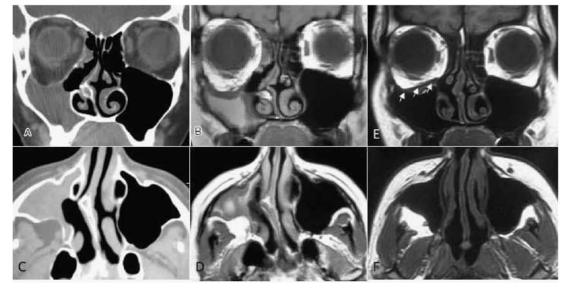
Preoperative A) CT in coronal plane shows opacification and atelectasis of the right maxillary sinus with downward displacement of the orbital floor, a septal spur is narrowing the right nasal fossa. The middle turbinate lies on the medial orbital wall. B) T1 weighted MR in coronal plane shows downward displacement of the orbital floor with resulting increase of orbital volume. Maxillary sinus is reduced in volume end completely opacified C) CT in axial plane shows medial and posterior wall inward bowing with enlargement of the retroantral fat pad. D) MR in the axial plane: right maxillary sinus shrinking, retroantral fat enhancement is evident. Postoperative 6 months follow-up E) T1 weighted MR in coronal plane shows normal air content of the right maxillary sinus, orbital floor is symmetric with the contra lateral side, septal spur has been removed with normal patency of the nasal fossa and middle meatus. The Medpore graft is visible as void signal intensity replacing the orbital bony floor (white arrows). F) T1 weighted MR in axial plane shows medial and posterior wall recovery, normal air content into the sinus.
